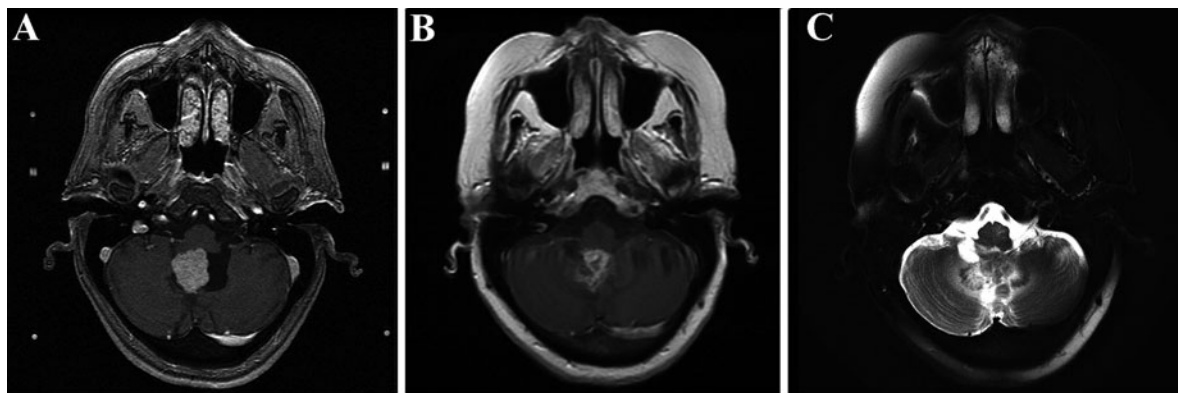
A 57 year-old woman was diagnosed with an ependymoma grade 2 of the fourth ventricle by surgical removal. Axial T1 weighted contrast enhanced MR images showing radio-surgery target at the time of SRS (a). Axial T1 weighted contrast
